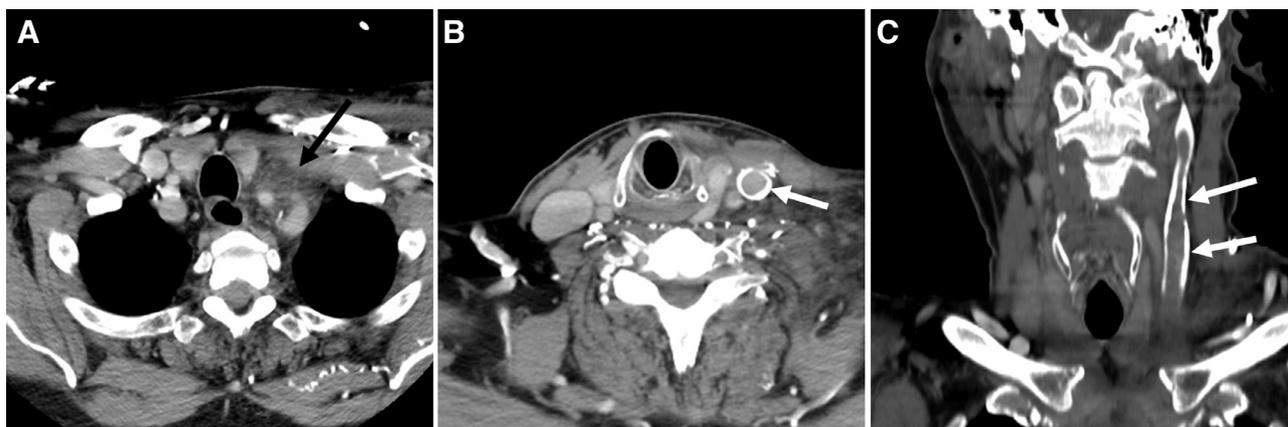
A 59-year-old female with a history of myasthenia gravis with a left internal jugular tunneled pheresis catheter who recently presented with fevers and chills. Infection was suspected and the catheter was removed. Axial (A,B) and coronal (C) reconstructions from a contrast-enhanced CT scan were performed to evaluate for infection which demonstrates inflammatory fat stranding within the left supraclavicular fossa (black arrow) suggestive of inflammation. There is a luminal filling defect within the left internal jugular vein outlined by contrast consistent with venous thrombosis (white arrows). These findings are consistent with catheter related septic thrombophlebitis.
